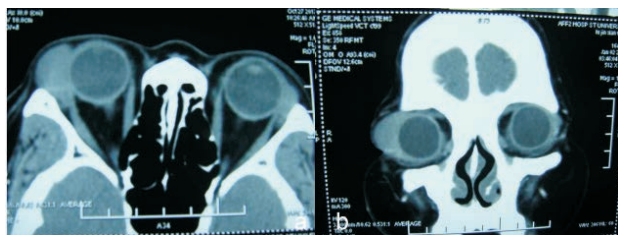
Computerized tomography (CT) scan. Mass in bilateral lacrimal gland region, more significant in right eye (a. horizontal position, b. coronal position)
